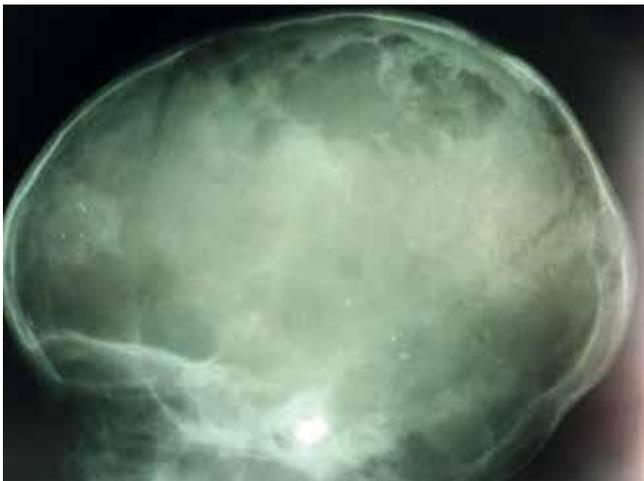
X-ray head lateral view showing multiple punched out lytic lesions, beveled margins and without sclerotic margins.
